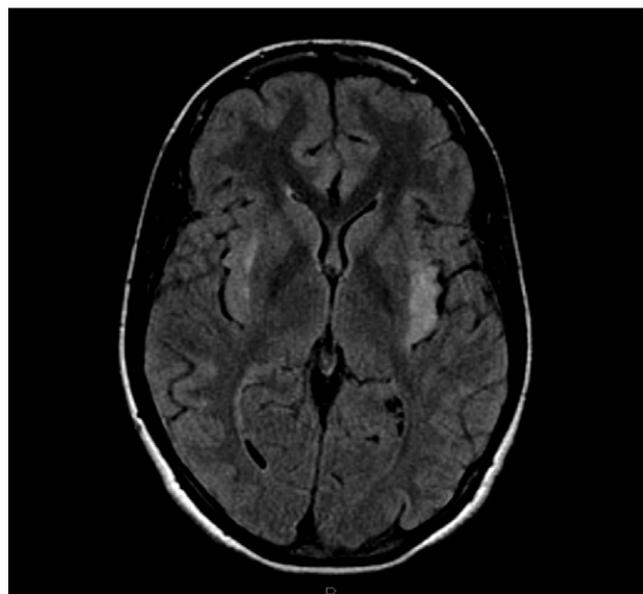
MR imaging in acute phase. Axial FLAIR sequences. Hyperintense area in both insular regions, more evident on the right.
